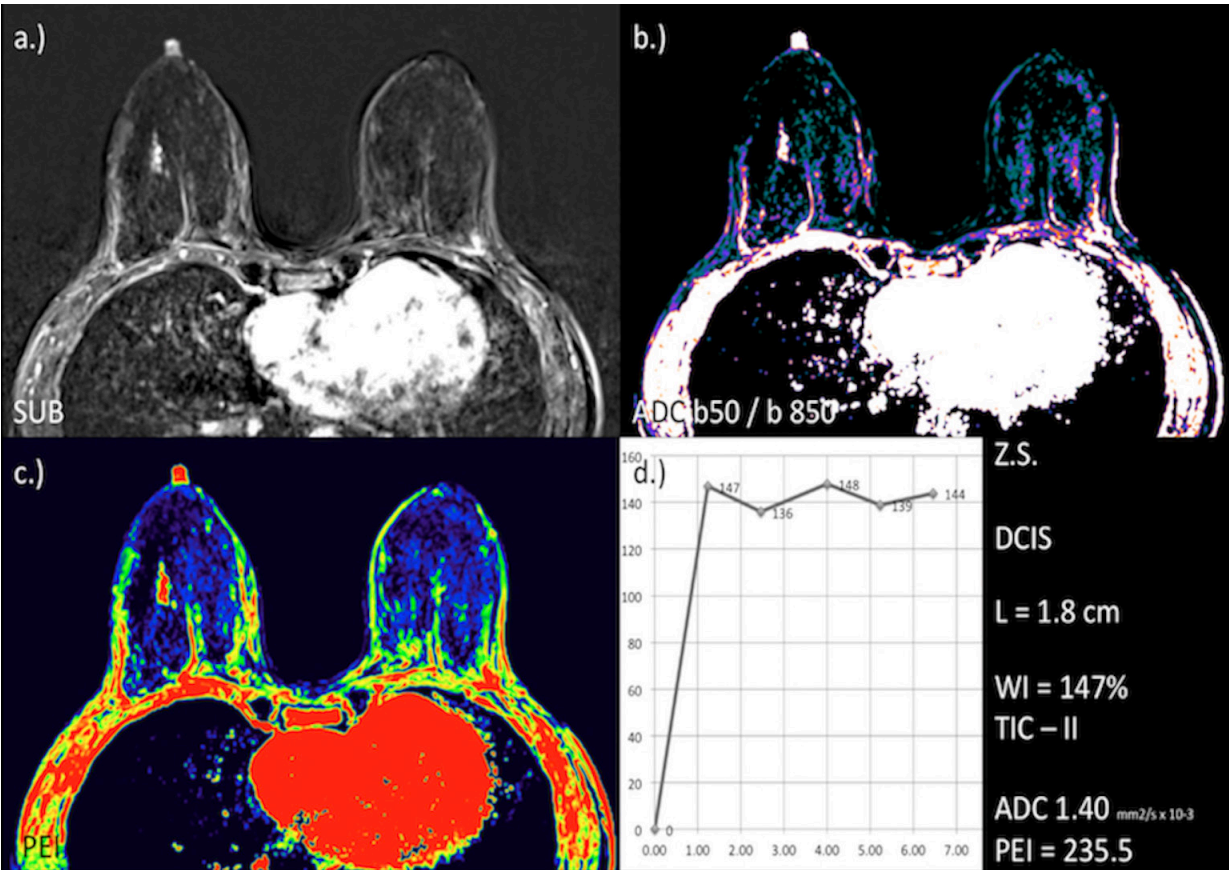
Morpho-dynamic and functional parameters of a 64-yr. old patient (Z.S.) with DCIS. (a) DCE-MRI, Subtraction (b) Diffusion Coefficient (ADC). (c) Positive Enhancement Integral (PEI). (d) Time-intensity curve.
